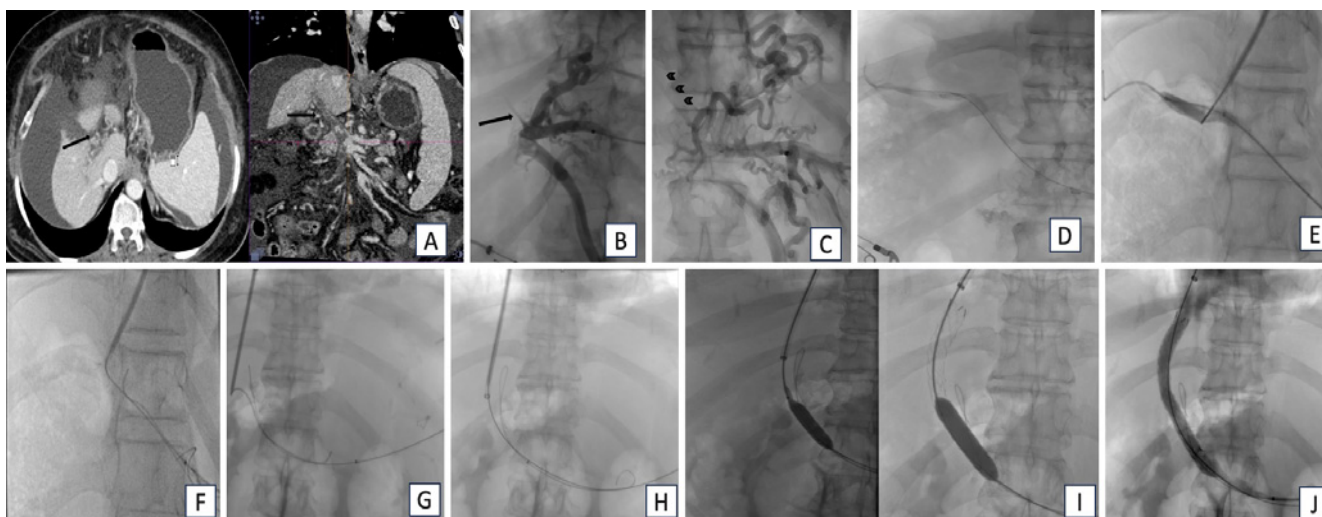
A 65-year-old man with hepatitis C cirrhosis. (A) Axial dynamic CT performed for transplant planning shows the absence of a patent portal vein and extensive cavernoma (black arrow). A completely thrombosed structured portal vein is seen extending up to the hepatic hilum (arrow). (B) Splenic Venography performed through the trans-splenic sheath confirms occlusion of the main portal vein with a thin residual channel in the expected position of the portal vein (black arrow). (C) The contrast tends to hold up within this residual channel of the thrombosed portal vein (arrowheads), which serves as a guide for recanalization. (D) Venography through the recanalized portal vein demonstrates the intrahepatic portal branches. (E) Transabdominal ultrasound and fluoro-guided puncture of a balloon placed in the right portal vein using transjugular intrahepatic portosystemic shunt (TIPS) cannula. (F) The exchange-length stiff glide wire is snared and withdrawn through the splenic sheath. (G) The stiff wire is exchanged with a working wire using a catheter. (H) After exchange for a working wire, the splenic sheath can be advanced into the portal vein over the through-and-through access. (I) Balloon dilation of the hepatic track and main portal vein is performed with a 10- and 12-mm high-pressure balloon respectively. (J) Portal venography after TIPS placement and portal vein recanalization shows a widely patent portal vein and TIPS. Note that the cavernoma is no longer opacified and should not compromise TIPS and recanalized portal vein patency by acting as a competitive outflow for portal flow.
